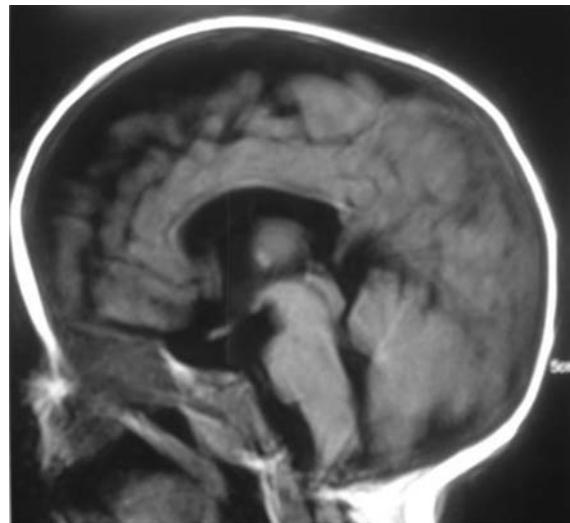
Bilateral frontotemporal subarachnoidal dilatation, corpus callosum hypoplasia and delayed myelination, and J-shaped sella turcica seen on cranial magnetic resonance imaging of brain.
